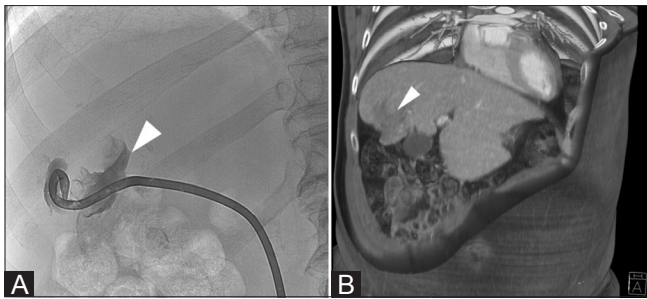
(A,B): After 6 months, fluoroscopy after iodinated contrast injection shows complete healing of the cysts and no communication with the biliary tree (A). Volume-rendered CT scan image (B) confirms the satisfactory result with a small residual collection within the right liver (arrow)
